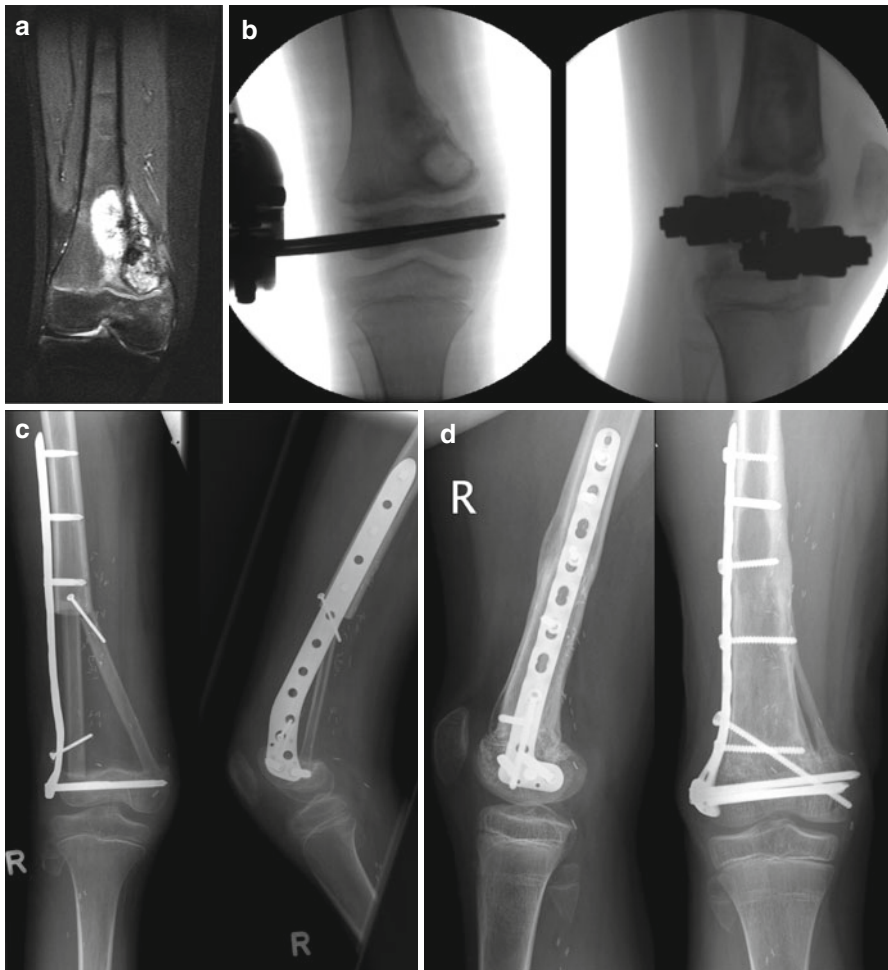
(a) Patient 2. Osteosarcoma in the distal femur. MRI after preoperative chemotherapy. (b) Physeal separation before definitive surgery. (c) Post-operative X-ray after reconstruction with a free microvascular allograft. (d) Definitive healing after additional allograft
